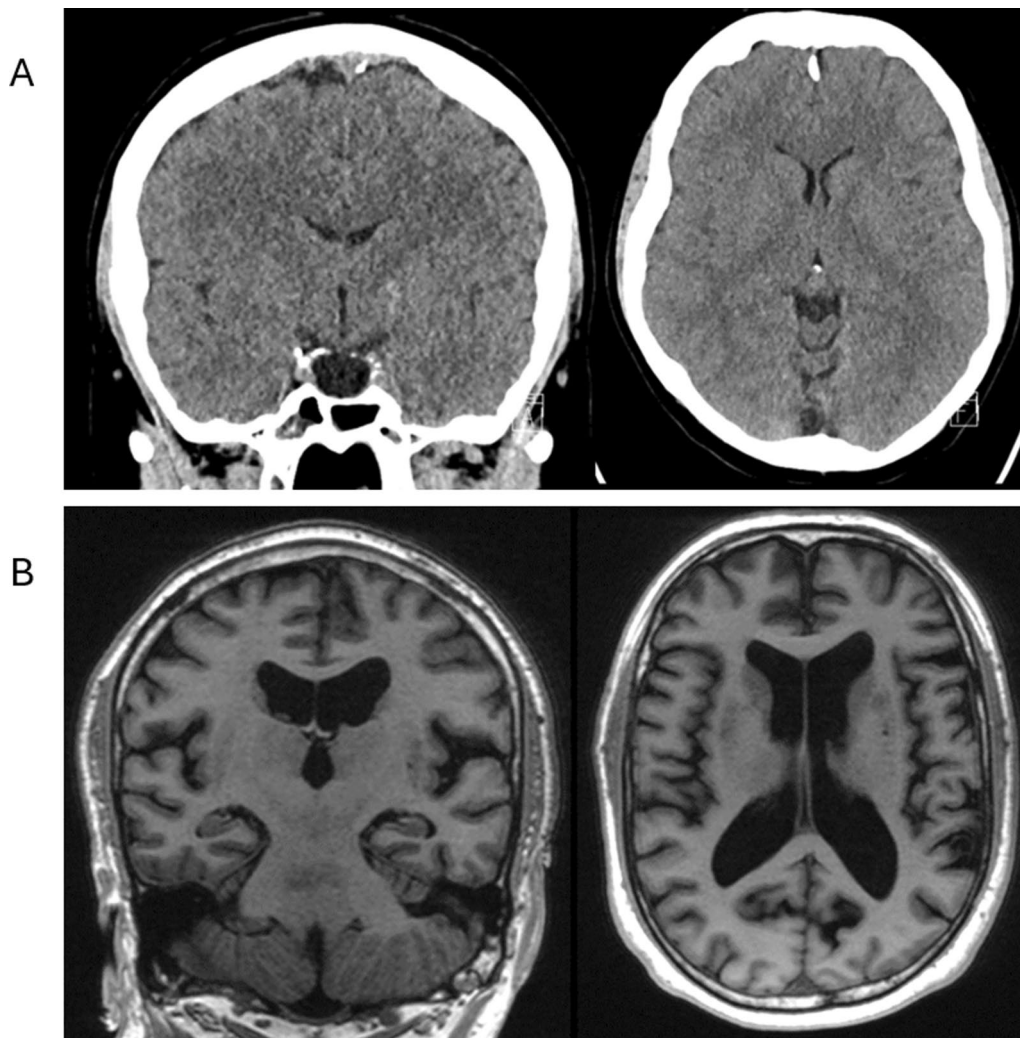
Brain imaging of asymptomatic relatives carrying heterozygous *CWH43* variants. A CT images of a 52-year-old Leu533Ter carrier, showing no ventricular enlargement. B MRI images (T1-weighted) of a 68-year-old Lys696AsnfsTer23 carrier, revealing asymptomatic ventriculomegaly (Evans Index 0.34) with no DESH
